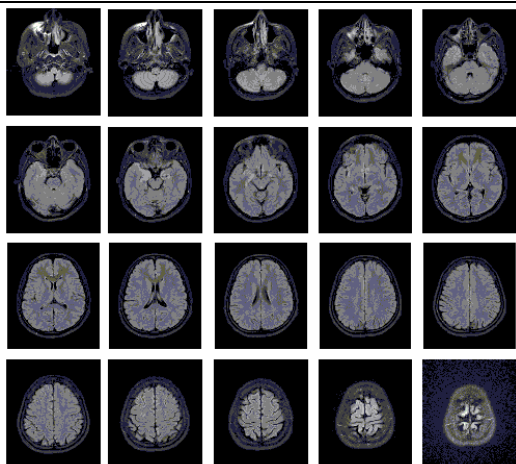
Axial MRI scans of 35 year old female healthy subject (Sample 1)
